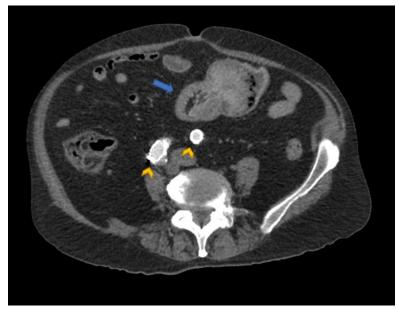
Contrast-enhanced arterial-phase and reformatted axial oblique computed tomography demonstrates small bowel intussusception, as well as fat and mesenteric vessels (blue arrow), at the level of the jejunoileal transition, in the left mesogastrium. As an additional finding, an aortobiiliac vascular prosthesis is observed at the level of the common iliac arteries (yellow arrowheads).
